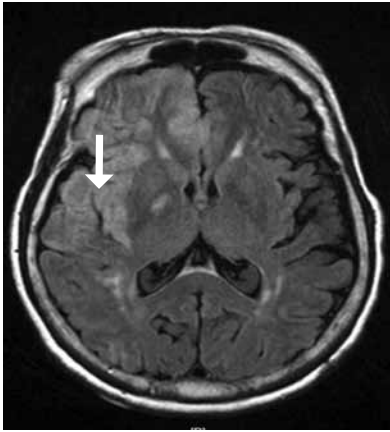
b – FLAIR MRI - Region of stroke
